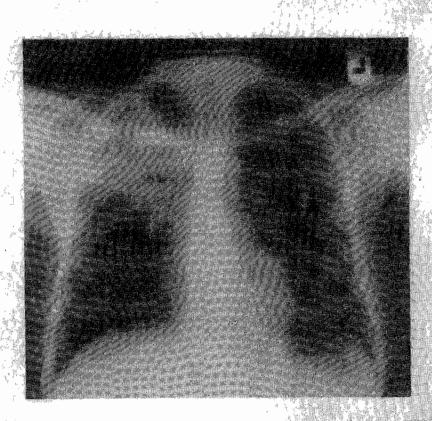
Chest x-ray showing right apical opacity with cavitations in HIV/PTB patient with CD4 count ≥200 cells/µl
